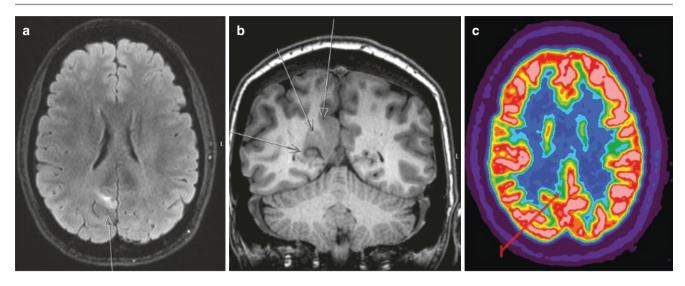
A 40-year-old female with medically refractory seizures. Coronal T1 BRAVO (a) shows the area of cortical thickening and blurring of the gray-white matter junction (*arrows*). Axial CUBE T2 FLAIR (b) with associated signal abnormality (*arrow*). Concurrent PET (c) demonstrates corresponding interictal hypometabolism in the medial right parietal lobe (*red arrow*). Findings consistent with FCD
